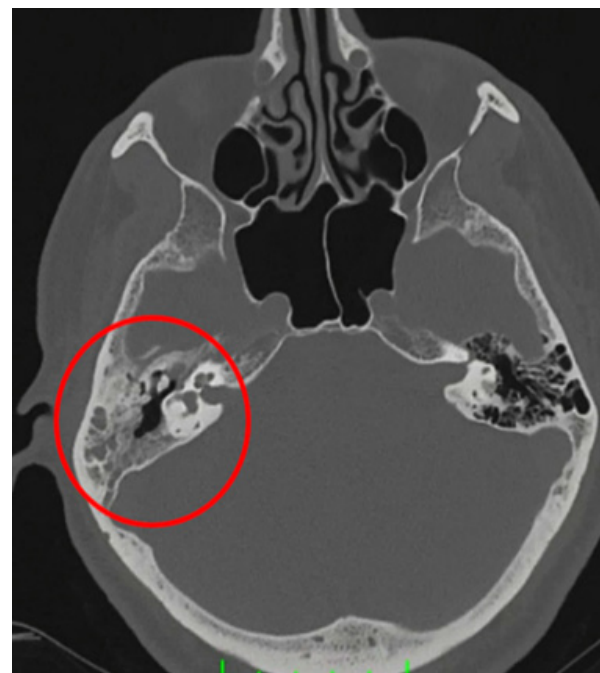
CT imaging showed significantly reduced aeration in the right mastoid air cells and middle ear. Increased density was observed due to mucosal thickening and effusion. No destruction was noted along the facial nerve canal.
